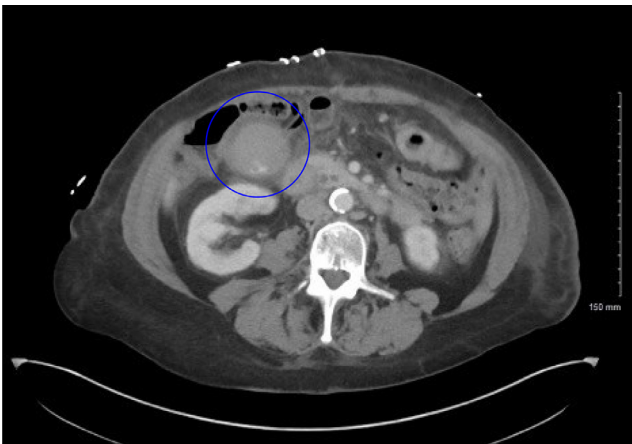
Axial CT with contrast of the abdomen, there is high density within the gallbladder (blue circle).
